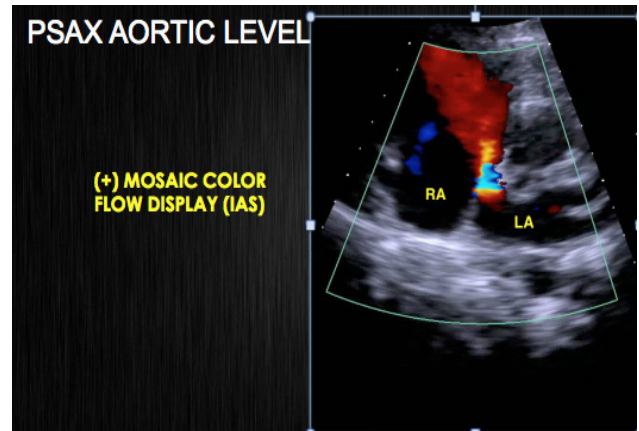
A parasternal short axis view 2 dimensional echocardiogram at the level of the aortic valve showing mosaic color flow display across the mid interatrial septum (IAS)
